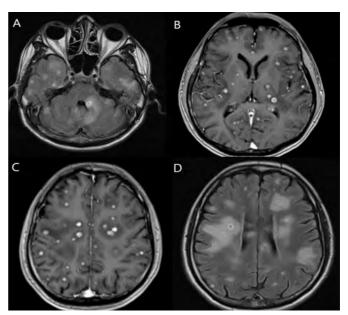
High-field Nuclear Magnetic Resonance images. A: Axial section in FLAIR (fluid-attenuated inversion recovery) sequence showing multiple rounded nodular lesions with annular enhancement and perilesional edema, distributed on the temporal lobes, cerebellum and left cerebellar peduncle. B and C: Axial section in T1 sequence after use of paramagnetic venous contrast with gadolinium showing rounded nodular lesions, with predominantly annular enhancement, moderate perilesional edema on the brain hemispheres. D: Axial section in FLAIR demonstrating perirolandic region with multiple rounded nodular lesions with surrounding edema in the parenchyma of bilateral brain hemispheres, predominating in the periventricular regions.
